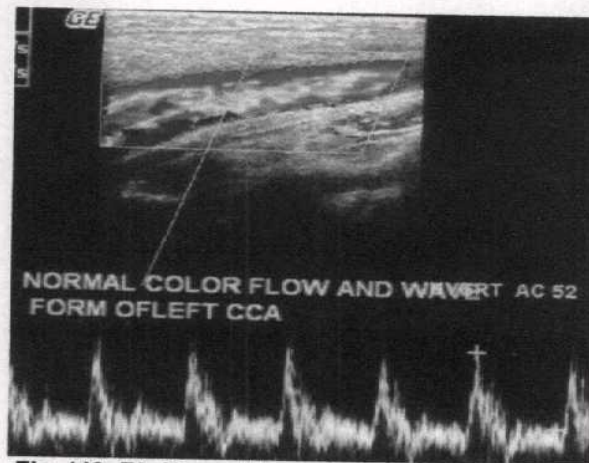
B): Normal Doppler waveform of CCA.
